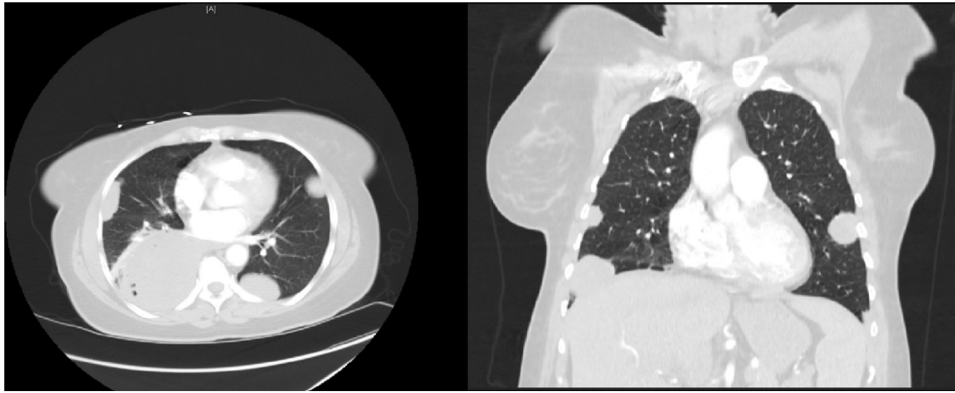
Computed tomography angiogram of chest. Large posterior right lower lobe heterogeneous lesion with several foci of gas. Other bilateral pulmonary masses are also noted.
